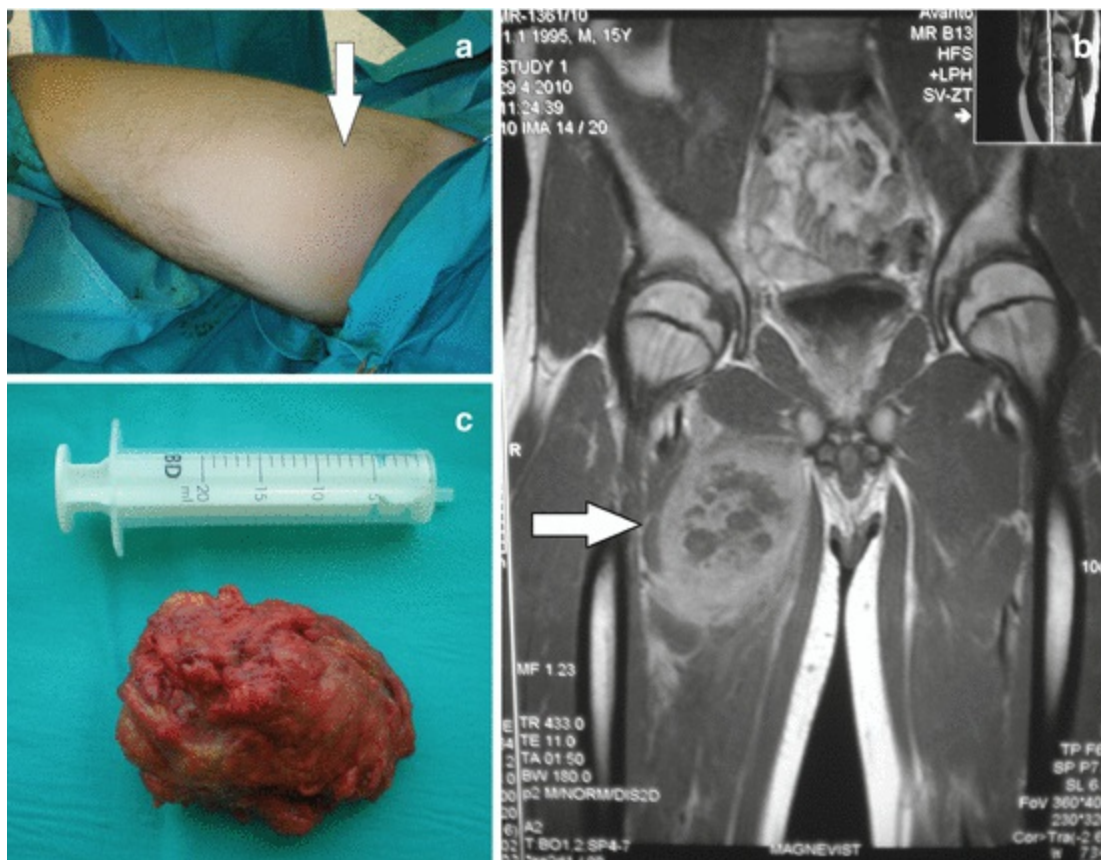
pPNET: (a) tumor of the right femoral region tumor; (b) preoperative magnetic resonance imaging; (c) complete excision of the tumor
